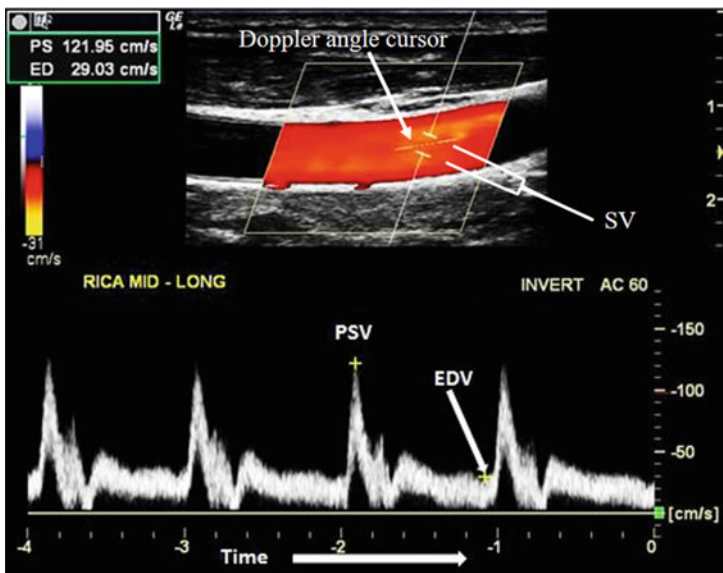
Spectral Doppler tracing showing the placement of measurement calipers to determine the peak systolic velocity (PSV) and the end diastolic velocity (EDV). The X-axis represents time and the Y-axis represents velocity. Note that the Doppler angle cursor is parallel to the long axis of the vessel and that the sample volume (SV) is positioned in the center of the lumen
